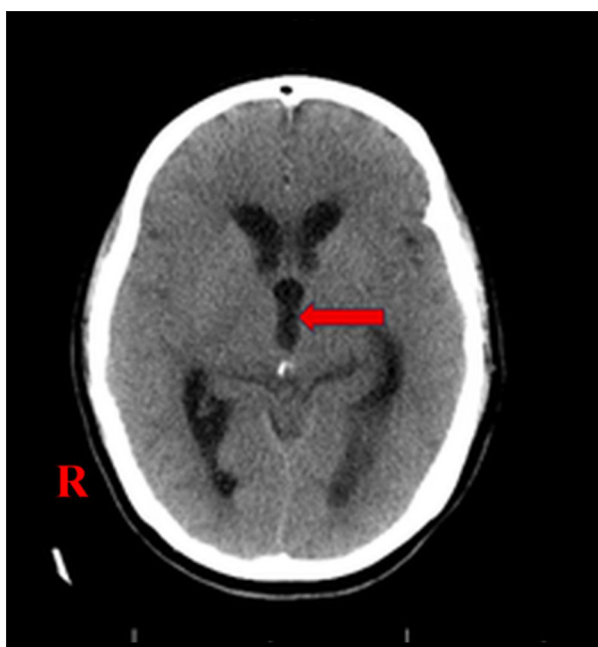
A non-contrast computed tomography scan of the head was obtained 3 days after admission due to worsening mental status. The third ventricle is dilated to 14 mm (red arrow). 'R', right side.
